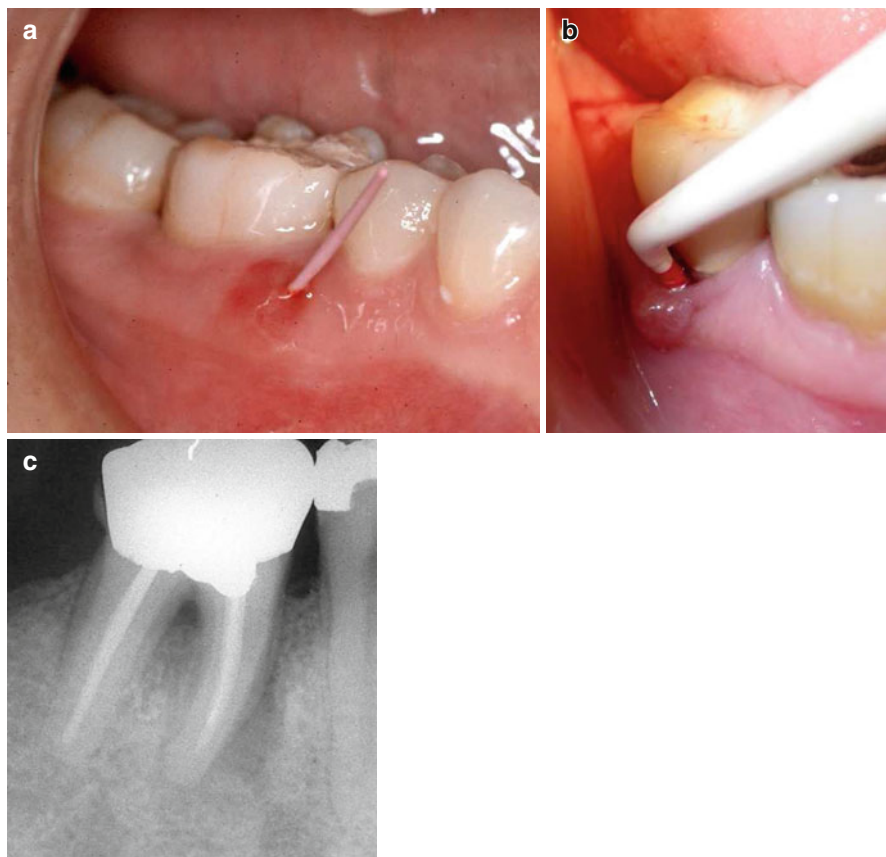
Common findings: (a) A highly located sinus tract in a mandibular molar. (b) A highly located sinus tract and deep probing in midbuccal area of another mandibular molar. The periapical radiograph (c) shows a combined bony lesion in the bifurcation area and along the lateral aspect of the mesial root which is typical for VRF in mandibular molars. The combination of the clinical signs in the endodontically treated tooth is considered pathognomonic for VRFs
